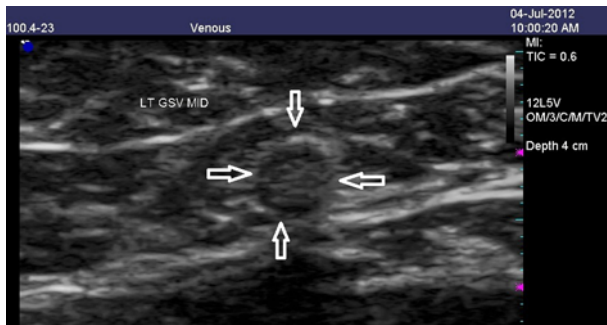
Successful mid-thigh GSV closure. Ultrasound image after one year. GSV, great saphenous vein
